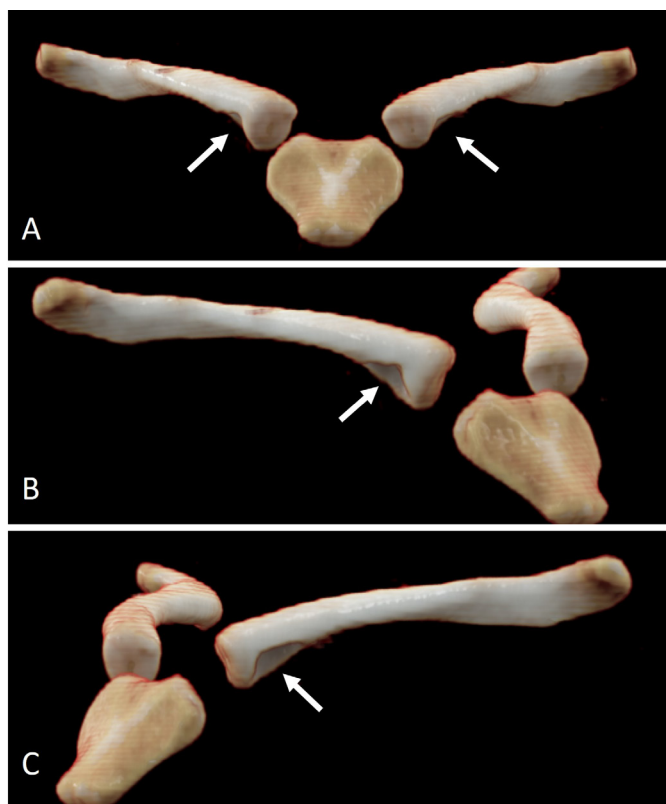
Computed tomography 3D (three dimensional) image, posterior-anterior and lateral projection; bilateral excavated type of RFs (arrows).
